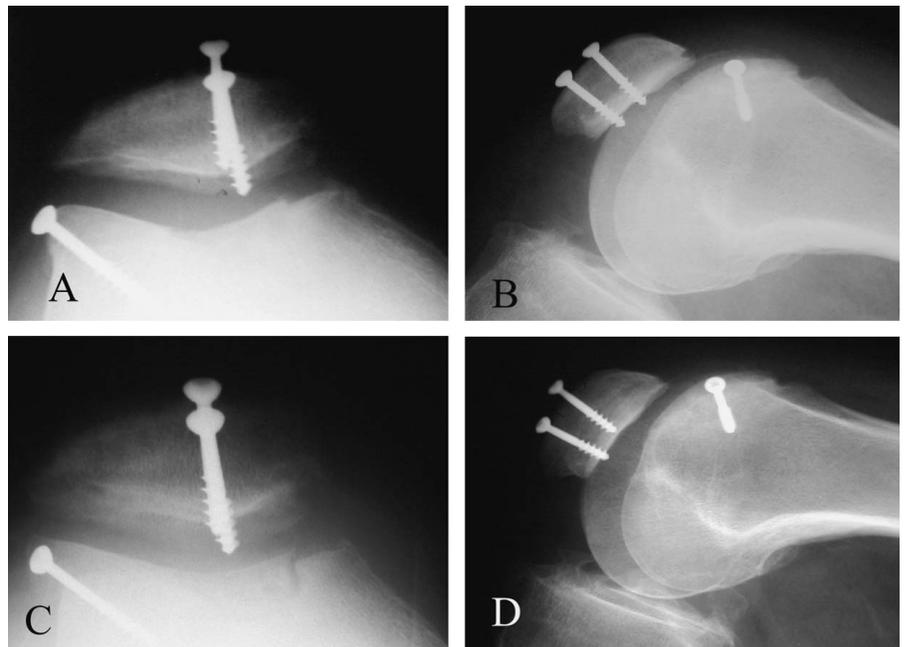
A 64-year-old patient with patellar and trochlear defects was treated with osteochondral allografting of both lesions. Early postoperative (A) Merchant and (B) lateral radiographs show the patellar and trochlear grafts. At 4 years postoperatively the (C) Merchant and (D) lateral radiographs indicate excellent incorporation at the host-graft interface, absence of sclerosis, lucency, fracture, and lack of progression of patellofemoral arthrosis.
